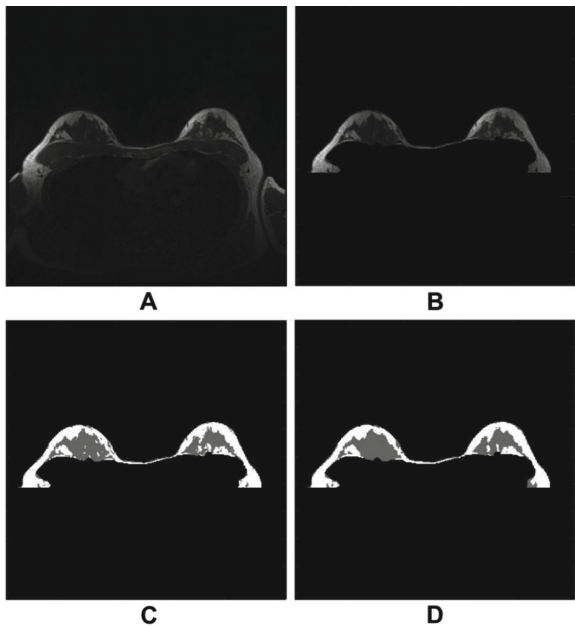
(Subplot A) Axial slice of a 3-D breast MRI volume; (Subplot B) Same slice contaminated by a bias field and Rician noise; (Subplot C) Segmentation obtained using the GMM-based method of [18]; (Subplot D) Segmentation obtained using the proposed method.
